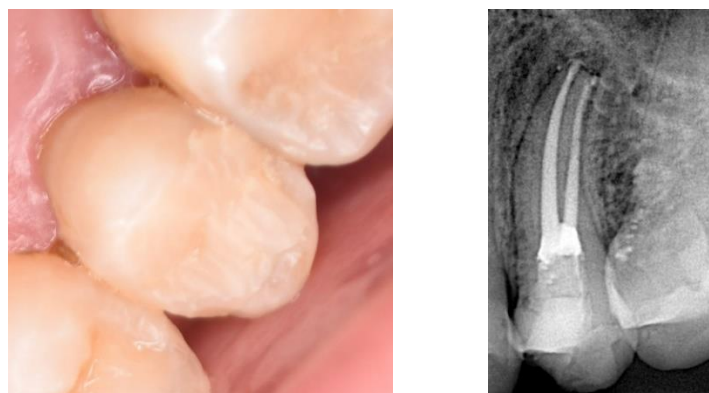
One-month follow-up radiograph and clinical
